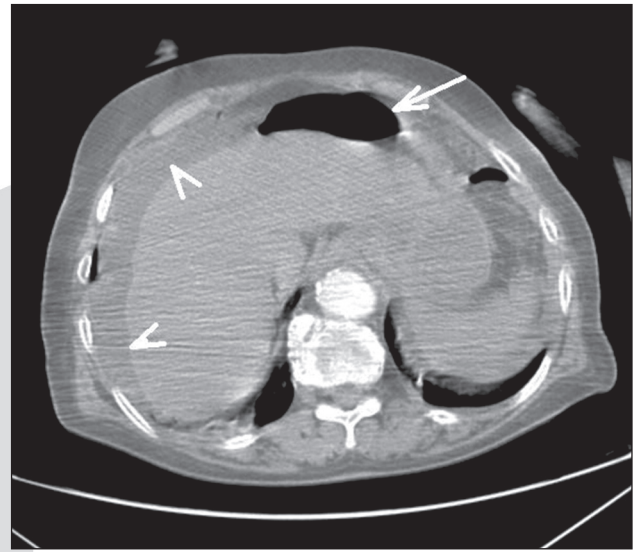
Axial CT scan of 37-year-old female patient shows extraluminal free air adjacent to left lobe of liver (arrow), and free fluid in perihepatic region (arrowhead) are observed.
